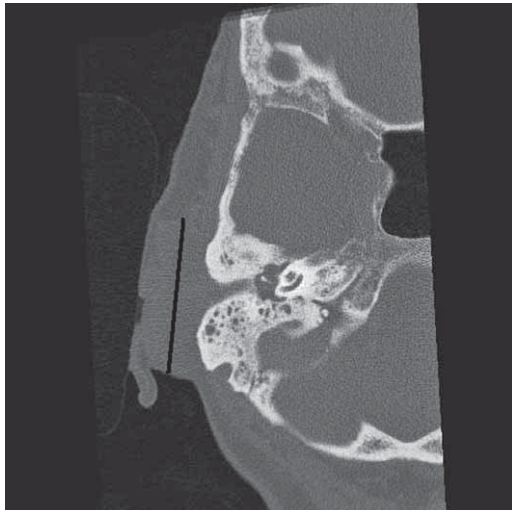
CT scan: tumor mass of the external auditory canal.
